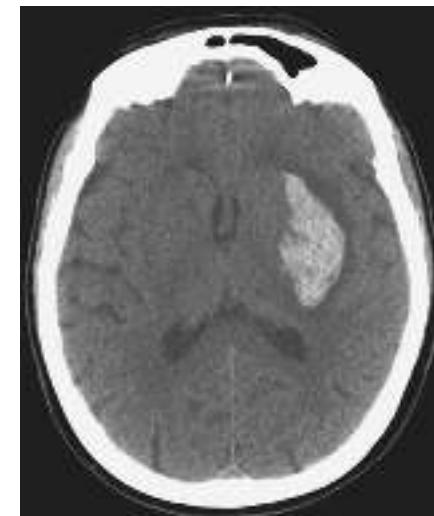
Hypertensive hemorrhage. Transaxial noncontrast computed tomography scan through the region of the basal ganglia reveals a hematoma involving the left putamen in a patient with rapidly progressive onset of right hemiparesis.
